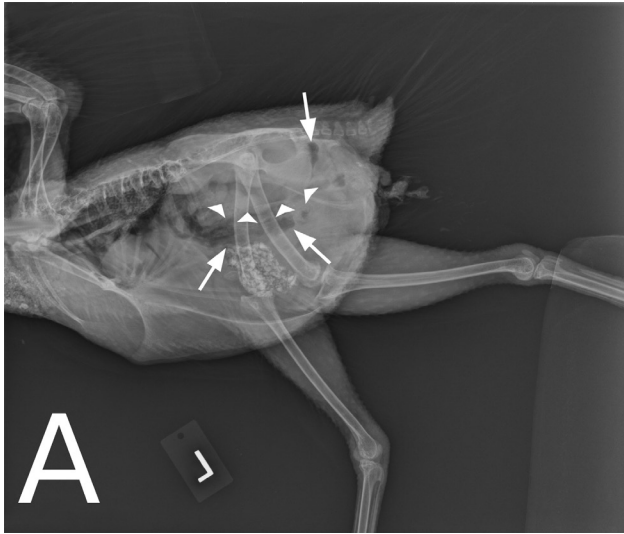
Same radiographic images as in Figure 1. A—Ventral to the synsacrum, a poorly defined and slightly lobulated soft tissue mass is present (arrowheads), compressing the caudal abdominal air sac as well as ventrally displacing the intestines (long arrows). B—The soft tissues surrounding the pelvic limbs are asymmetric in size, with the left pelvic limb being approximately half the size of the right pelvic limb, indicating muscle atrophy (thin double arrows). The hepatic silhouette is mildly wide (wide double arrow).
